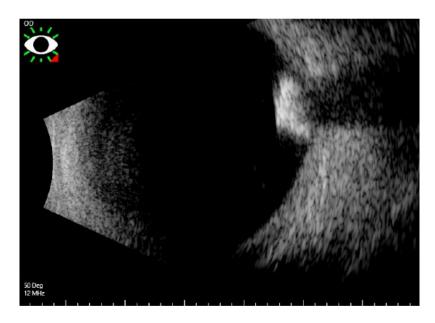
B-scan ultrasonography of the right eye with retinoma
